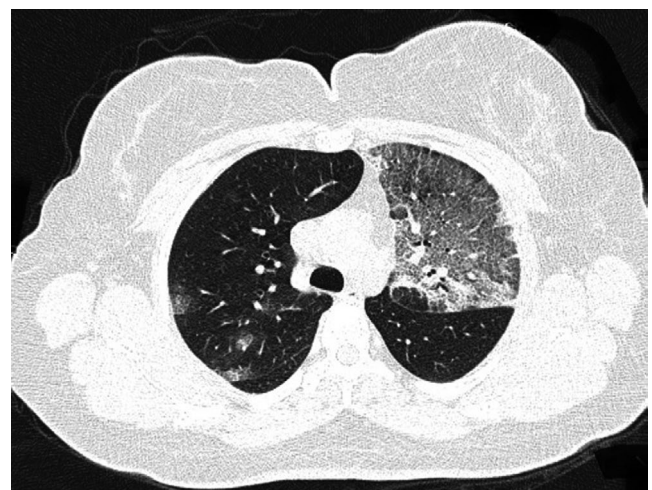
Chest HRCT of a 41-year-old woman showing ground-glass opacification in the left upper lobe changing into irregular reticulation.
